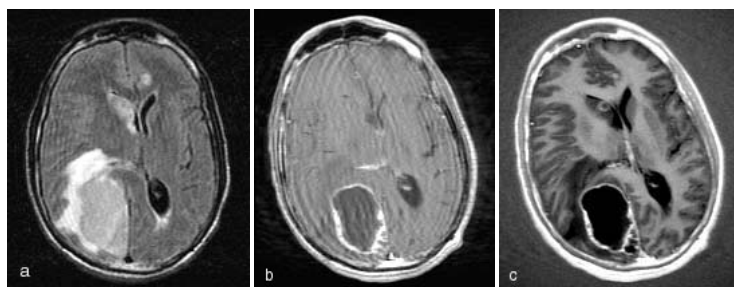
Images from a patient with multiple cerebral abscesses. Several well circumscribed mass lesions with perilesional edema are seen on the T2 FLAIR (a); Post Gd scan of T1SE (scan time of 2:28) (b) and PS-T1IR (scan time of 1:25) (c) demonstrate the lesion perfusion area. The lesion was hypointense in PS-T1IR and hyperintense on T2FLAIR. Again the superior contrast obtained with PS-T1IR relative T1SE can be observed on this figure.
